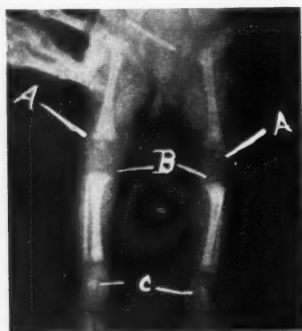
Radiograph of a normal infant twelve days after birth (see description of case, Mrs. H. B. S., General Number 5368). The mother previously had given birth to 2 children who had been overweight at birth and had proved to be both mentally and physically retarded. She received combined thyropituitary treatment after the fourth month of this pregnancy. The infant's weight at birth was 7 pounds, 8 ounces. Note the presence of the osseous nuclei of the lower epiphysis of the femur, upper epiphysis of the tibia, and two tarsal bones (talus and calcaneus).
